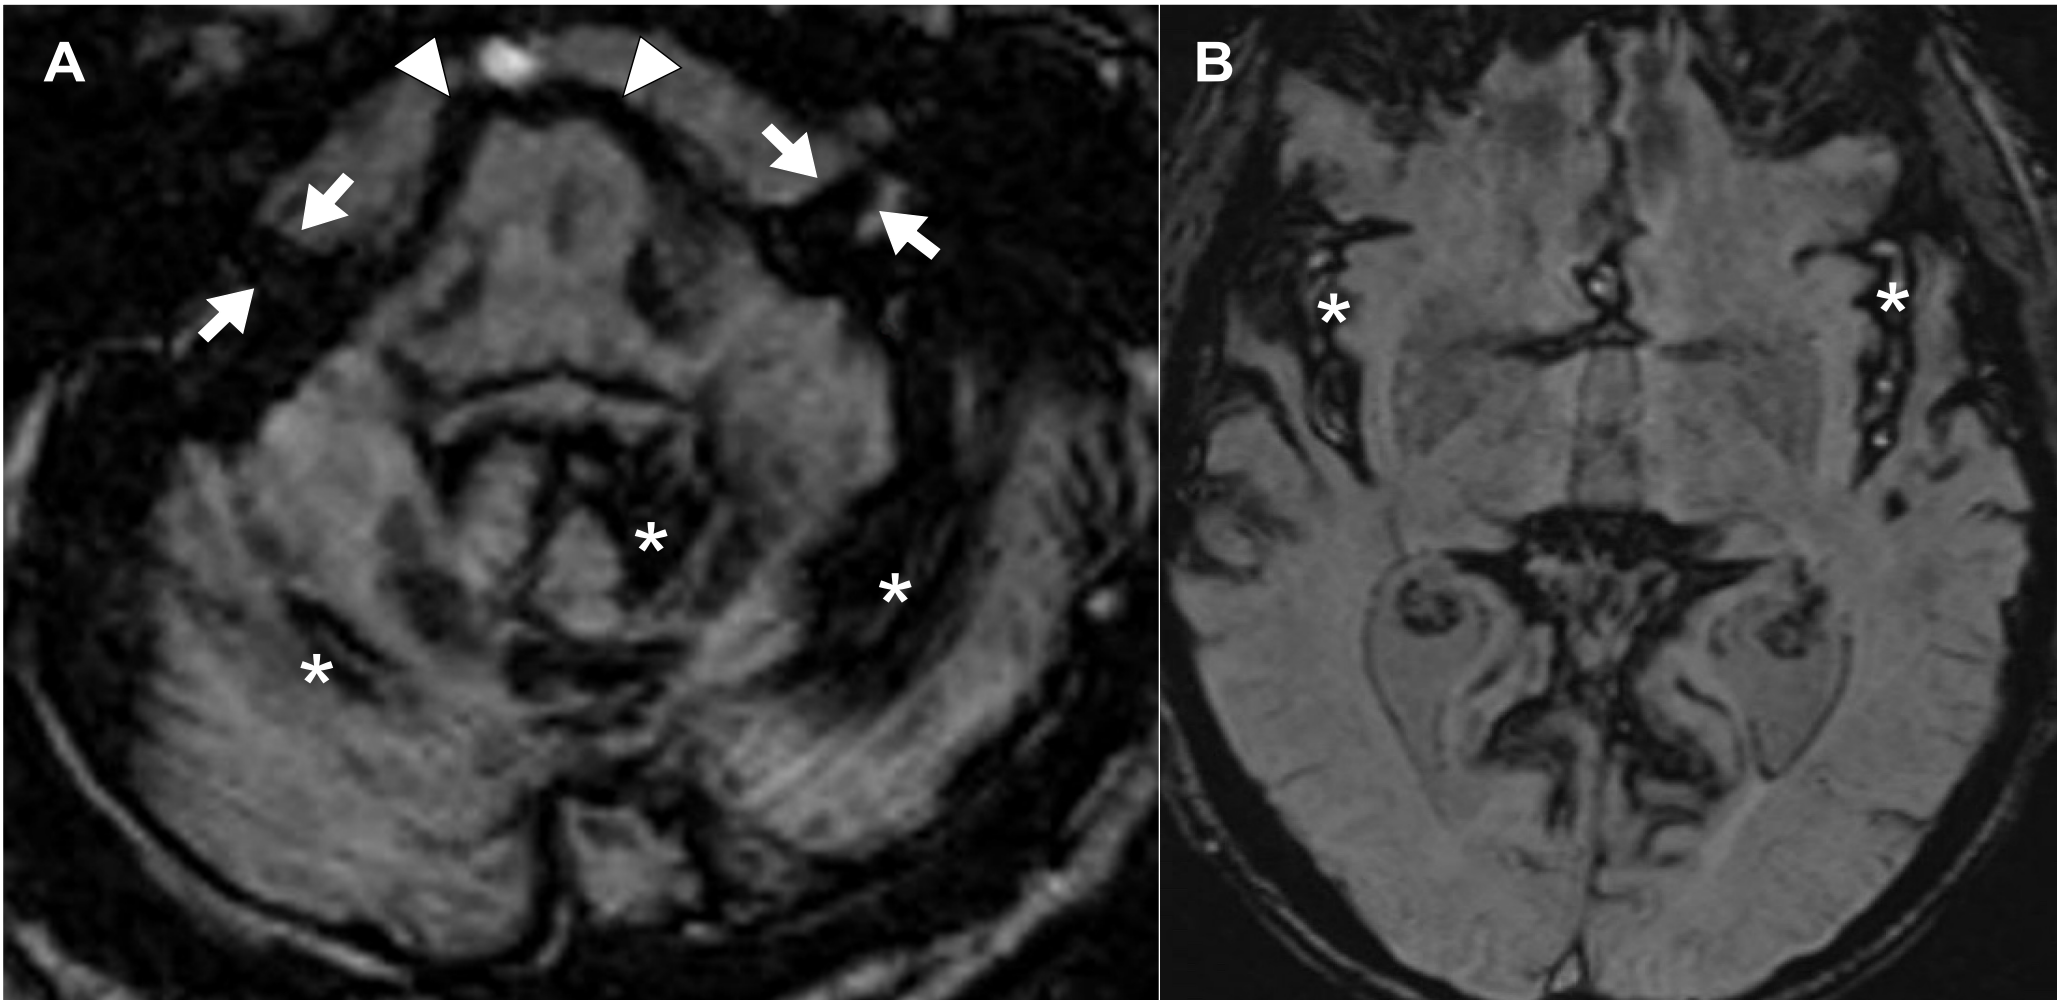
Axial susceptibility-weighted MR images with signal loss (consistent with hemosiderin deposits) involving A: cerebellum (asterisks), 8th cranial nerves (arrows) and brainstem (arrowheads); B: Sylvian fissures (asterisks).
